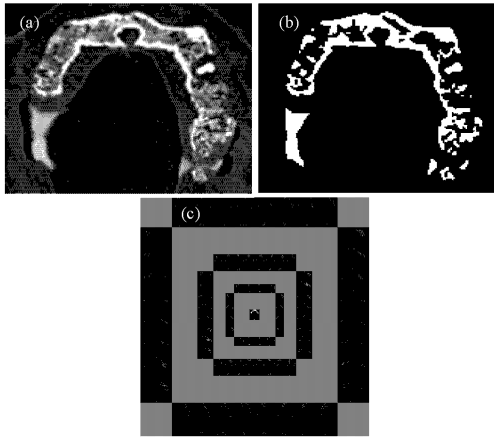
a) Original axial CT slice, b) Edge based segmented image, c) Region based segmentation
